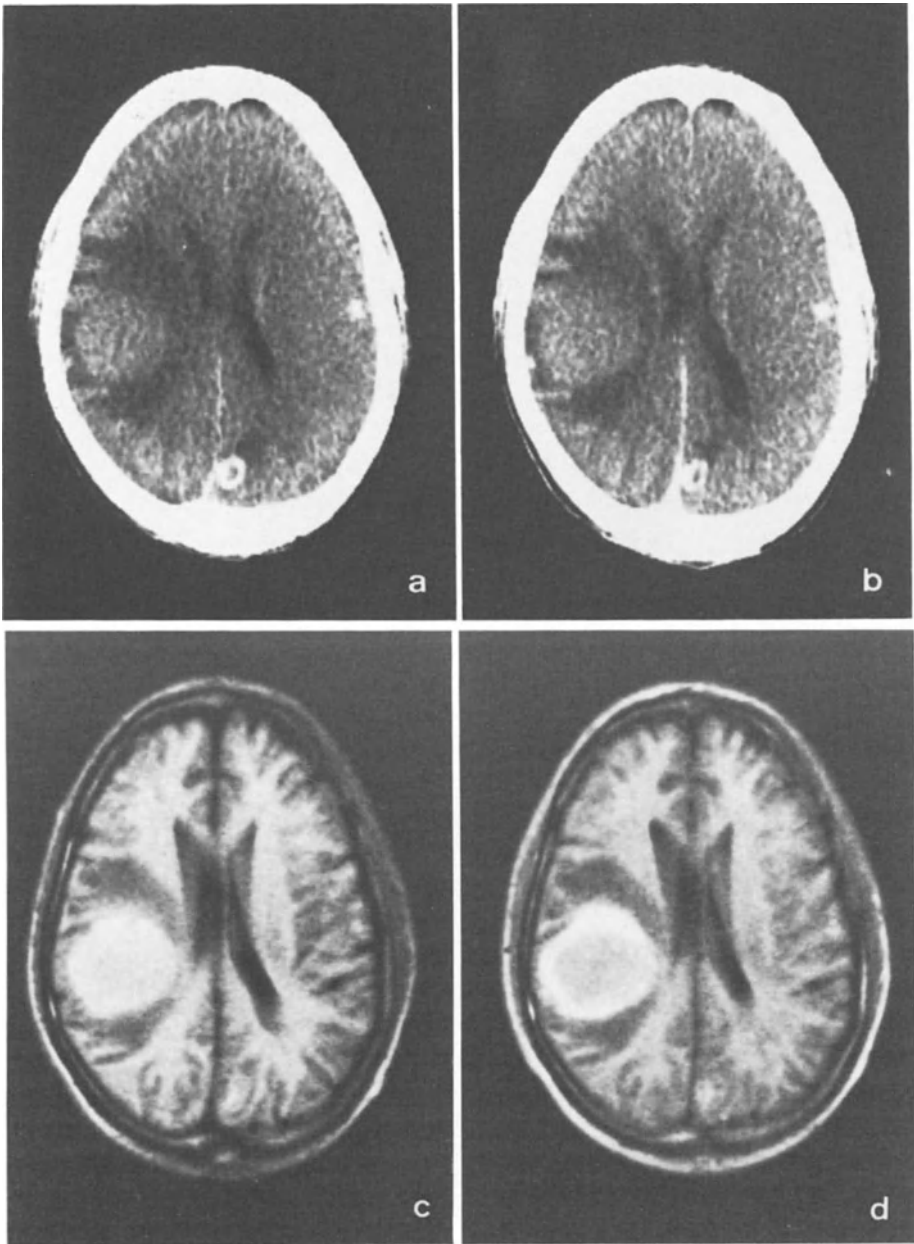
Metastatic malignant melanoma. a Nonenhanced CT scan. b Contrast-enhanced CT scan. c $IR_{1500/500/44}$ scan precontrast. Tumour demonstrates short T_1 with surrounding oedema. d $IR_{1500/500/44}$ post-paramagnetic contrast agent. [Gadolinium diethylene triamine penta-acetic acid (Gd-DTPA)]. Ring enhancement of tumour is seen with NMR but not with CT
